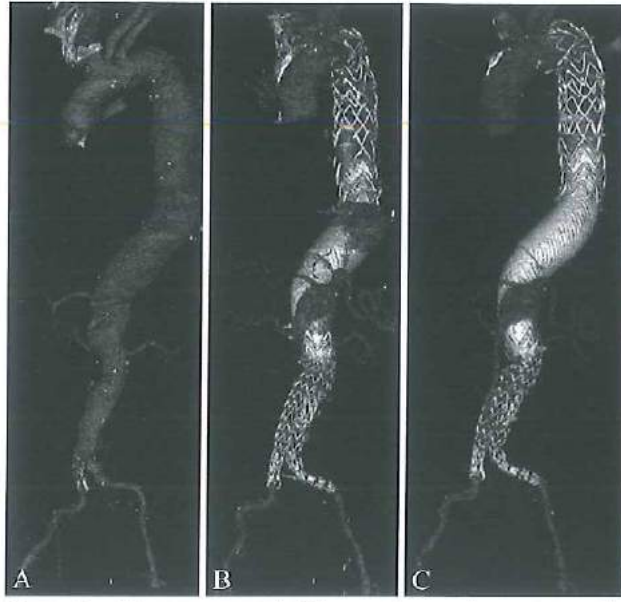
(A) pre-operative and (B) 1 month and (C) 6 months post-operative CT showing patency of branch vessels and thrombosis of the aneurysmal sac [Pane et al. 2013].
